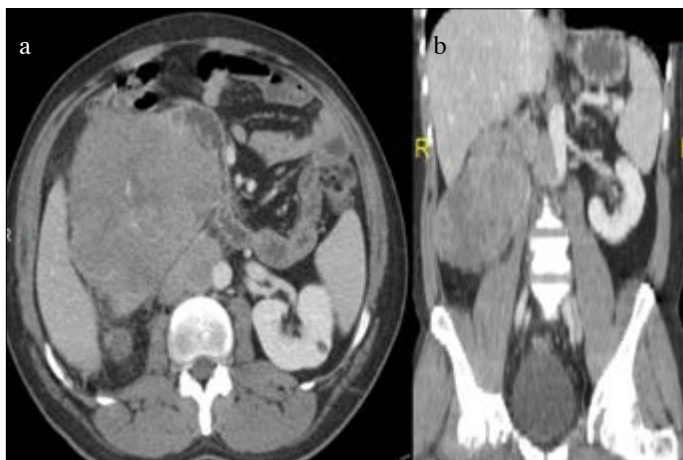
a, b. Right renal mass and metastatic lymph nodes in the interaortocaval and paracaval area on computed tomography [transverse plane (a) and frontal plane (b)]
